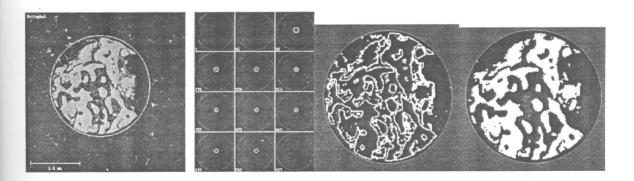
Micro CT analysis of Region interest (ROI)
